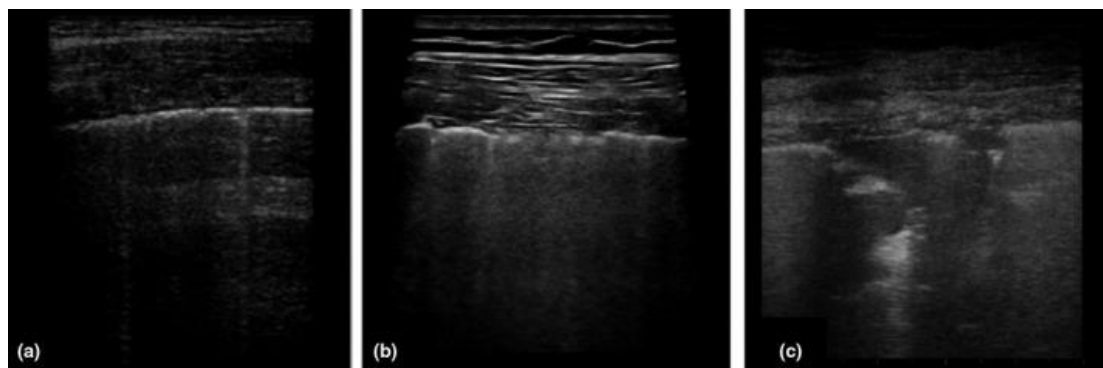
chest ultrasound COVID-19 patterns. (Pascarella *et al.*, 2020).
